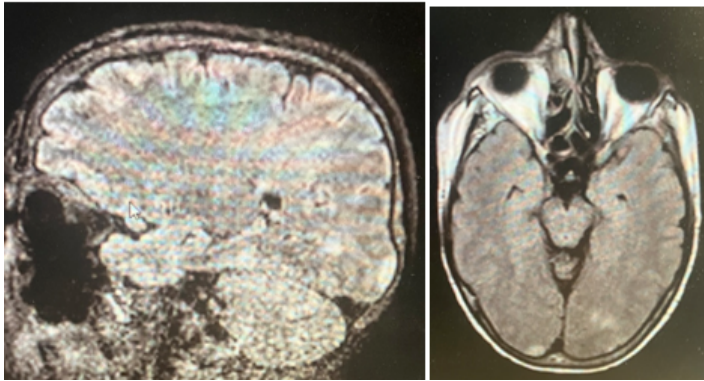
and 3E: MRI Brain showing Right occipital pole hyperintensity-suggesting edema due to PRES; 3D Sagittal FLAIR and 3E Axial FLAIR.
